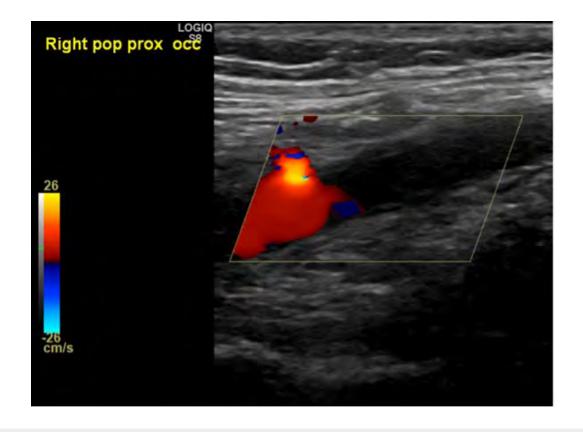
Ultrasound right lower limb with Doppler flow.
